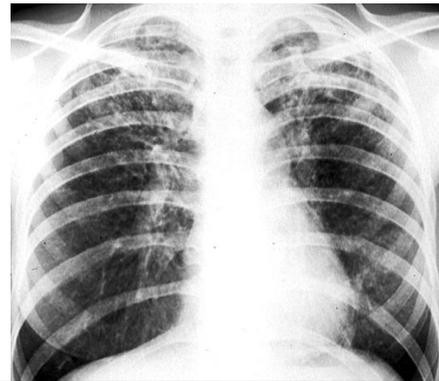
Chest radiograph demonstrates the characteristic bilateral upper lobe consolidation associated with post primary tuberculosis.
